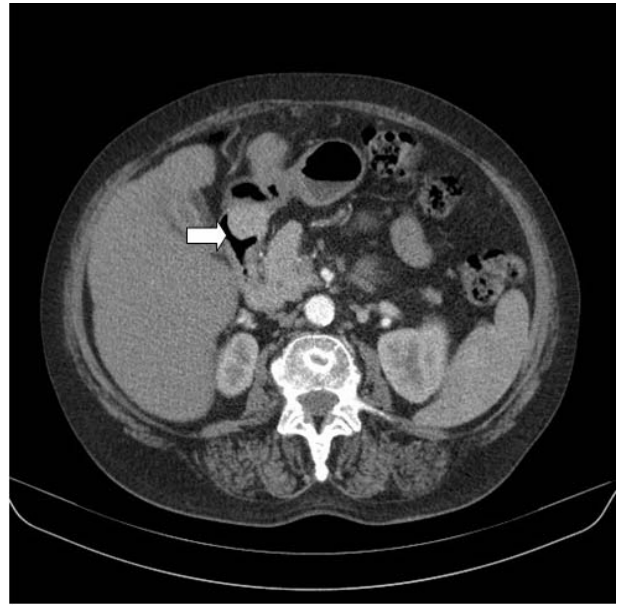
CT scan showing a pyloric lesion (arrow).
